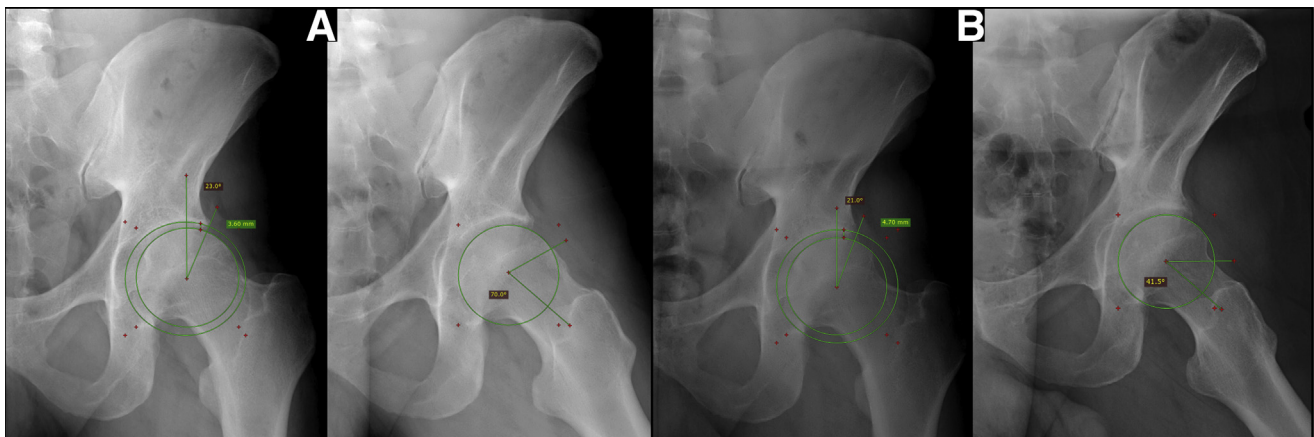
Anteroposterior (AP) and axial right hip radiographs of the presurgical and postsurgical evolution. The articular space maintenance at 37 months postsurgery can be observed, and with no degenerative sign progression: (A) Presurgical AP and axial radiography (α 70°, CE 23° articular space 3.6 mm), (B) Postsurgical radiography at 37 months, AP and axial (α : 41.5°, CE: 21° articular space: 4.7 mm).
